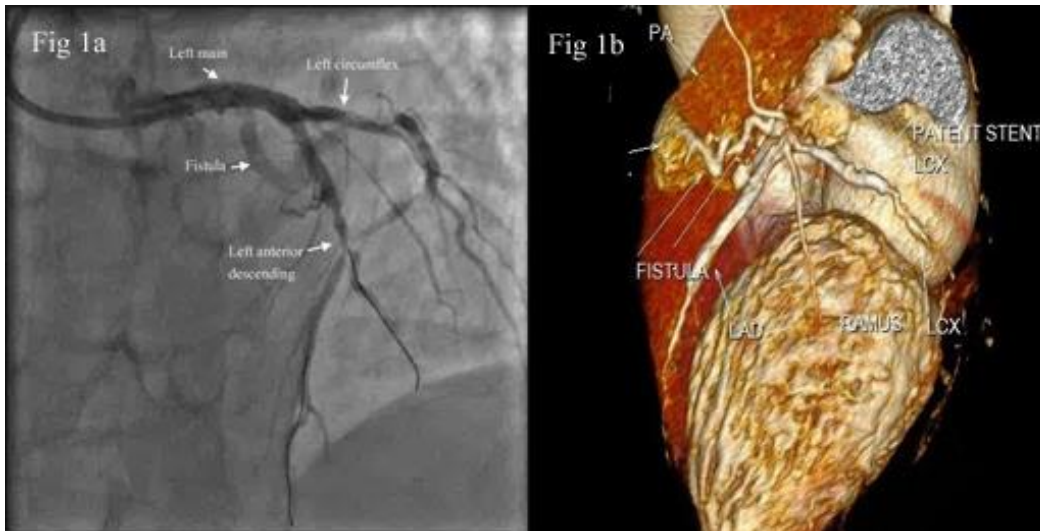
Coronary Angiogram; Figure 1b. CT Angiogram demonstrating Left main to pulmonary artery fistula
